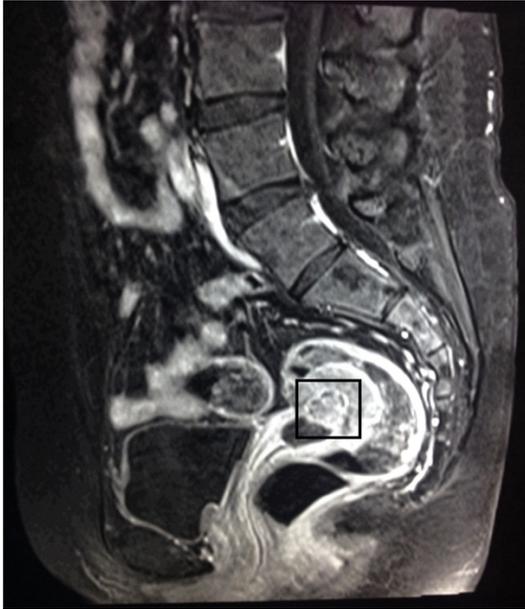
Magnetic resonance imaging (MRI) scan showing an endometriosis mass.
